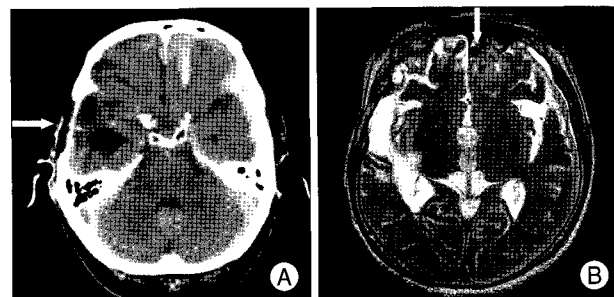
Axial computed tomography scan showing previous craniectomy site on the right temporal area (arrow), recent intracerebral hemorrhage on the left frontal lobe, and subdural hematoma on the left frontotemporoparietal area (A). T2-weighted magnetic resonance image showing multiple signal voids at the left frontal pole near the cranial base (arrow) (B).
